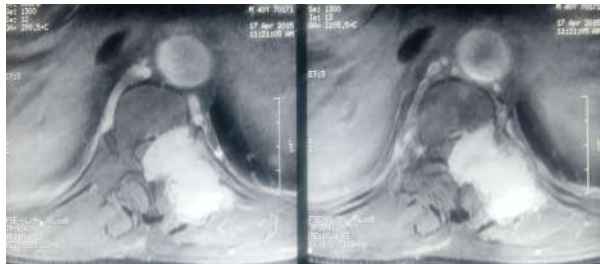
Contrast MRI Spine axial view showing homogenous enhancing mass involving dorsal spine and extending into paraspinal region and intraspinal cord compression in Ewing's Sarcoma spine patient
